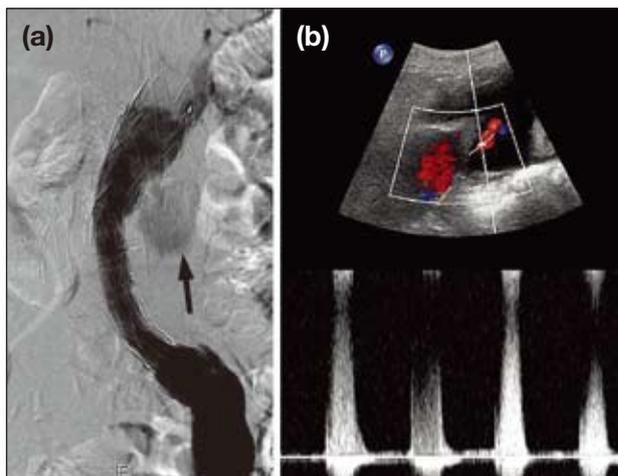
(a) Digital subtraction angiogram showing the site of fabric tear and type III endoleak (arrow); and (b) colour-flow Duplex sonogram showing arterial waveform at the site of the leakage.
